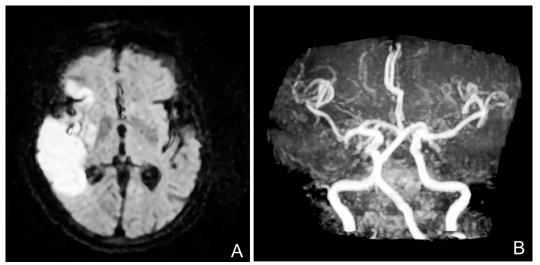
Brain MRI showed right MCA territory acute infarction. (A) Right MCA acute infarction (B) Right MCA stenosis.
